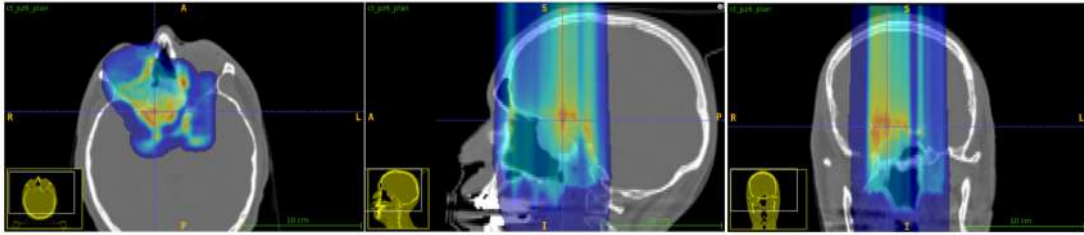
Dose distribution prescribed by the treatment plan, superimposed on the planning CT and visualized using ITK-SNAP. The dose map is expressed in arbitrary units, with the colour scale ranging from low (blue) to high (red) values.
